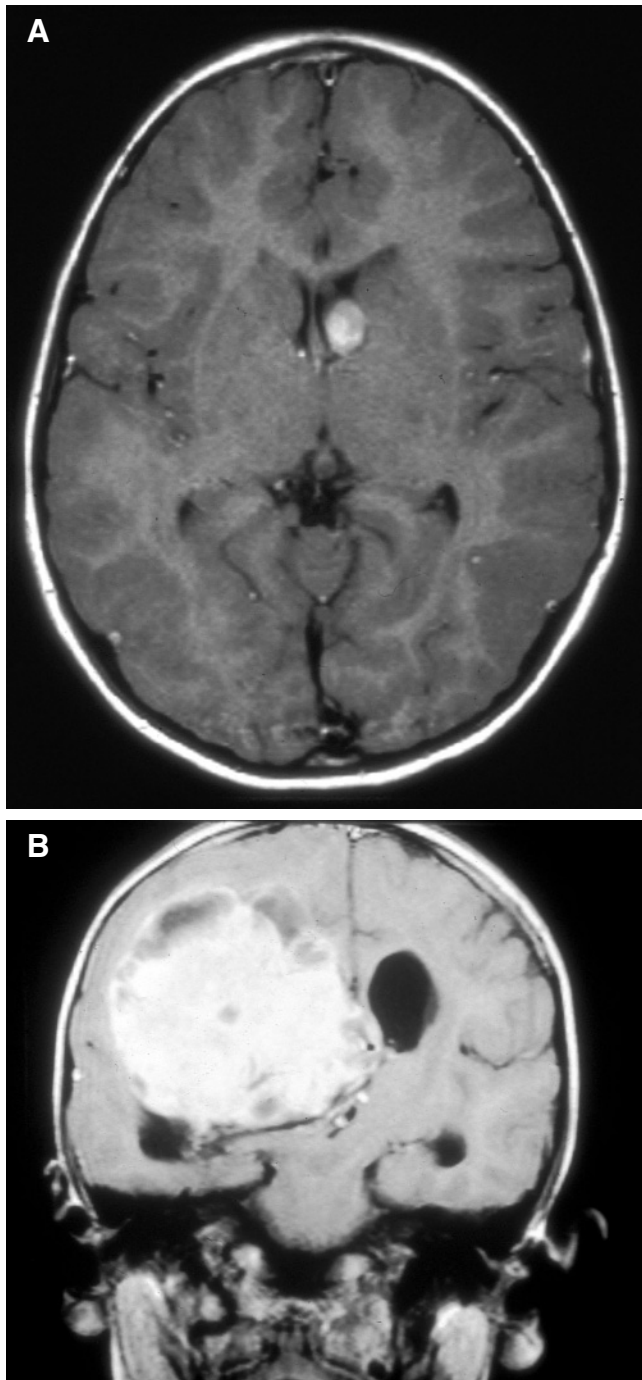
A*, Gadolinium-contrast T₁-weighted magnetic resonance image (MRI) from a child with tuberous sclerosis complex shows an enhancing subependymal giant cell astrocytoma protruding into the left frontal horn. *B*, Another patient's MRI with gadolinium demonstrates a huge subependymal giant cell astrocytoma filling much of the lateral ventricle.
